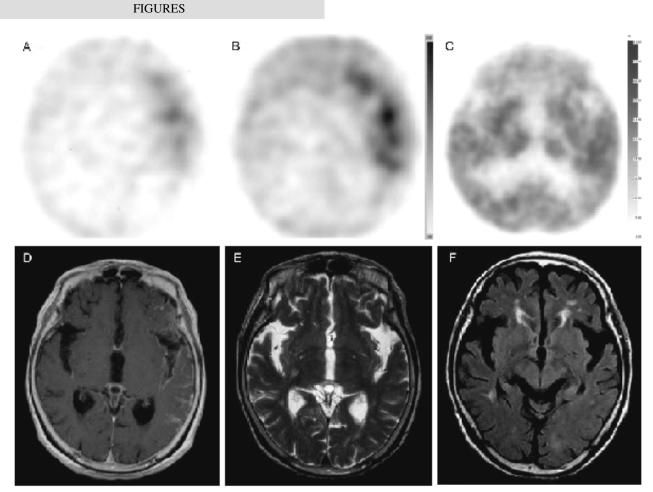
87 year old woman with neoplastic meningitis from gastric cancer. A gadolinium diethylenetriamine pentaacetic acid (Gd-DTPA) T1-weighted MRI image showing frontal and temporal meningeal enhancement. No enhancement was seen in the brain parenchyma (Panel D). A thallium-201 SPECT study of the brain at the same level showed abnormally strong uptake on delayed imaging (Panel B) and weaker uptake on early imaging (Panel A), consistent with the gadolinium enhancement of the meninges on MRI. FDG PET of the brain showed slight deoxyglucose uptake in the left temporal lobes as compared with the right hemisphere (Panel C). High-intensity regions were not evident on T2-weighted MRI or FLAIR images (Panels E&F).
